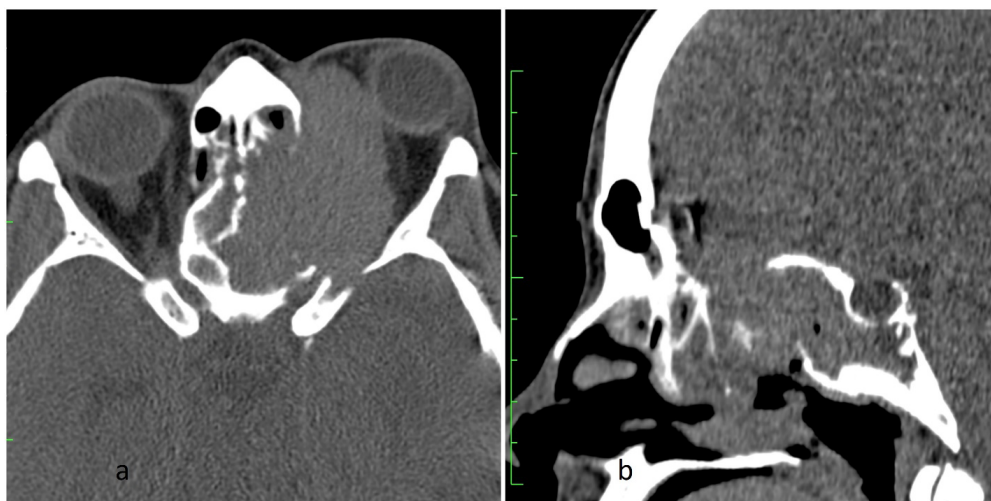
a) Axial, b) Sagittal CT scan
